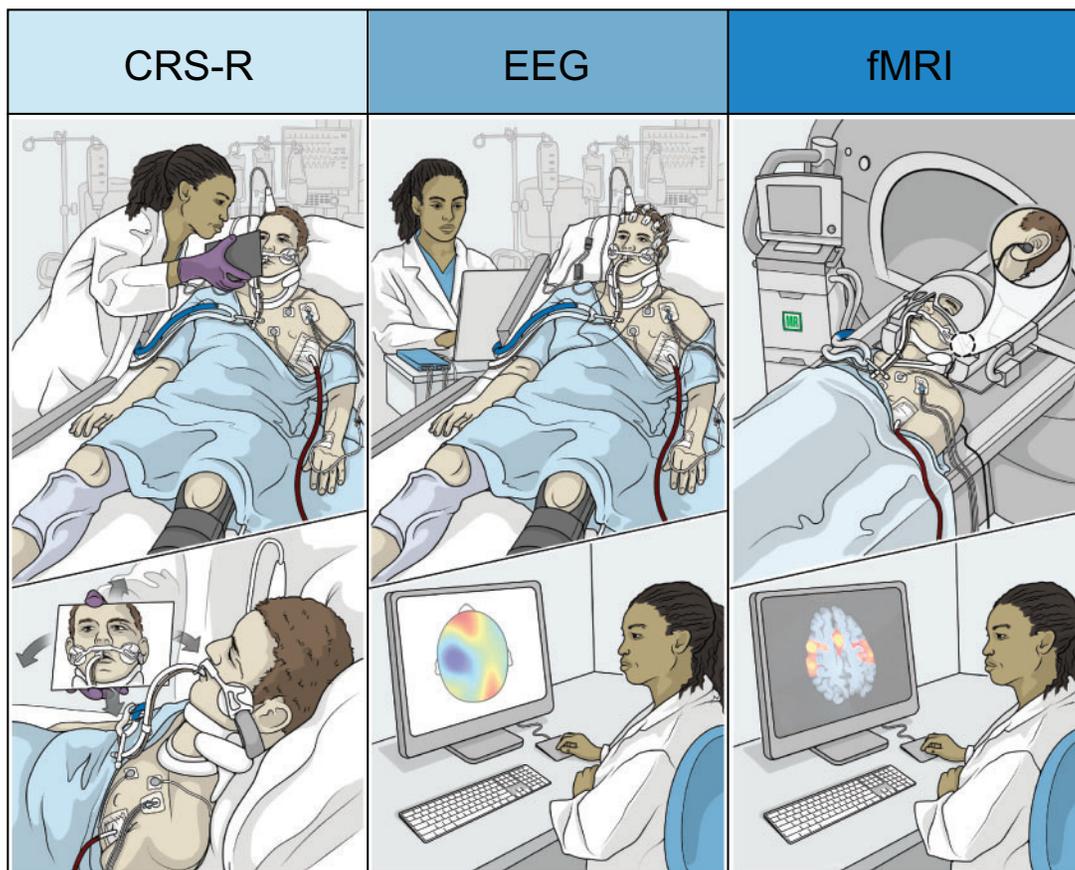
Expanding the detection of consciousness. Multimodal assessments, including neurophysiological and neuroimaging techniques such as EEG and functional MRI, can augment the sensitivity of bedside behavioural examinations and aid in the diagnosis and prognosis of DoC. A patient may be diagnosed with the highest level of consciousness assessed by each of these measures. Adapted with permission.²³⁴
